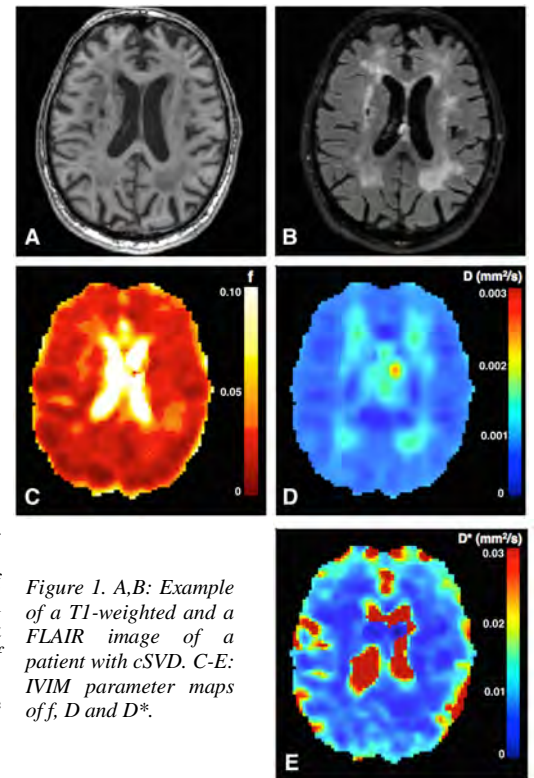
A,B: Example of a T1-weighted and a FLAIR image of a patient with cSVD. C-E: IVIM parameter maps of  $f$ ,  $D$  and  $D^*$ .
